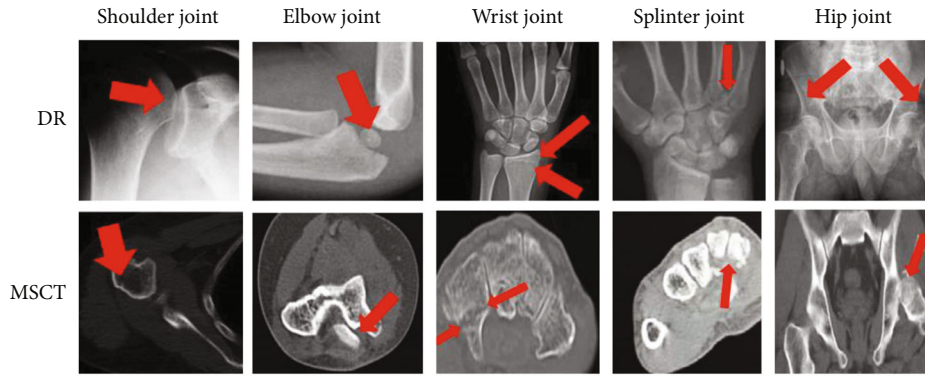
X-ray DR plain film and MSCT image.
